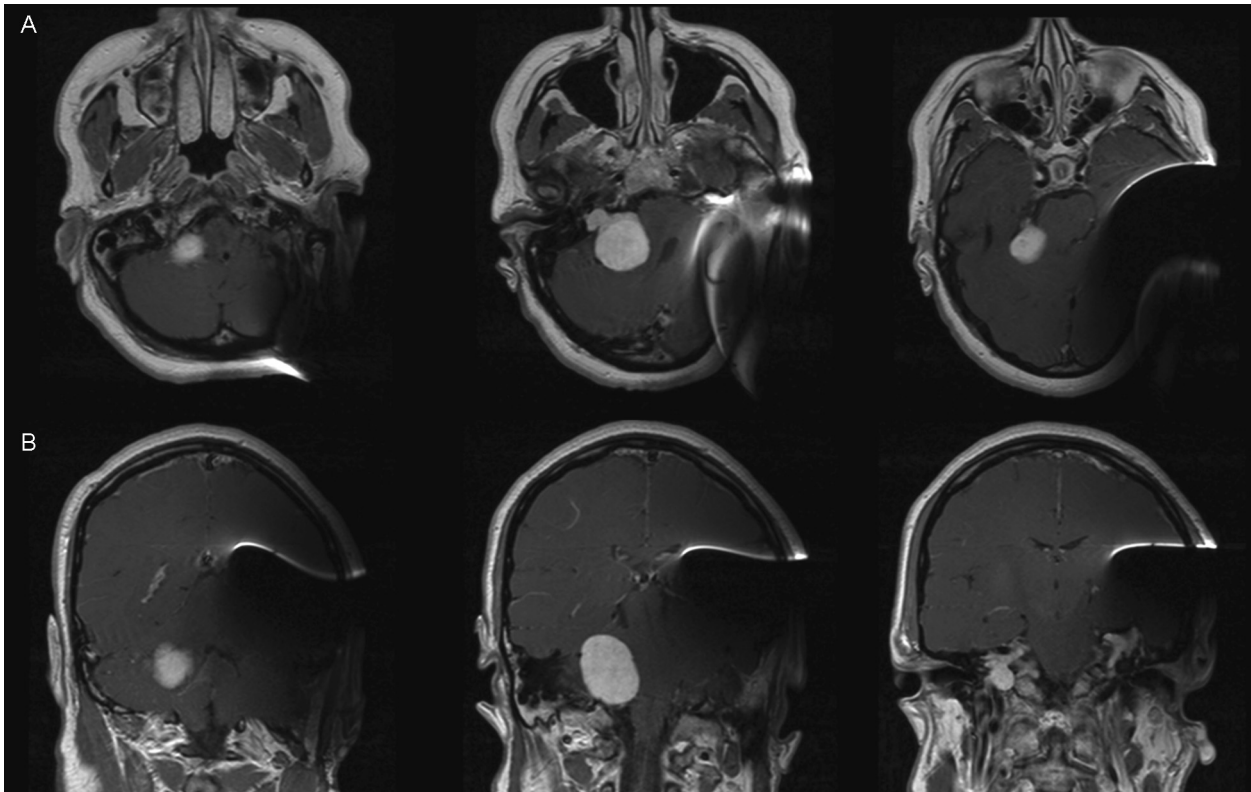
MRI with a Med-El Synchrony auditory brainstem implant (ABI) demonstrates clear and quality images of the contralateral homogeneously enhancing cerebellopontine mass. The ABI creates moderate metallic artifact distortion that limits evaluation of the ipsilateral cerebral and cerebellar hemispheres. (A) Axial view sequence from inferior to superior (left to right). (B) Coronal view sequence from anterior to posterior (left to right).
